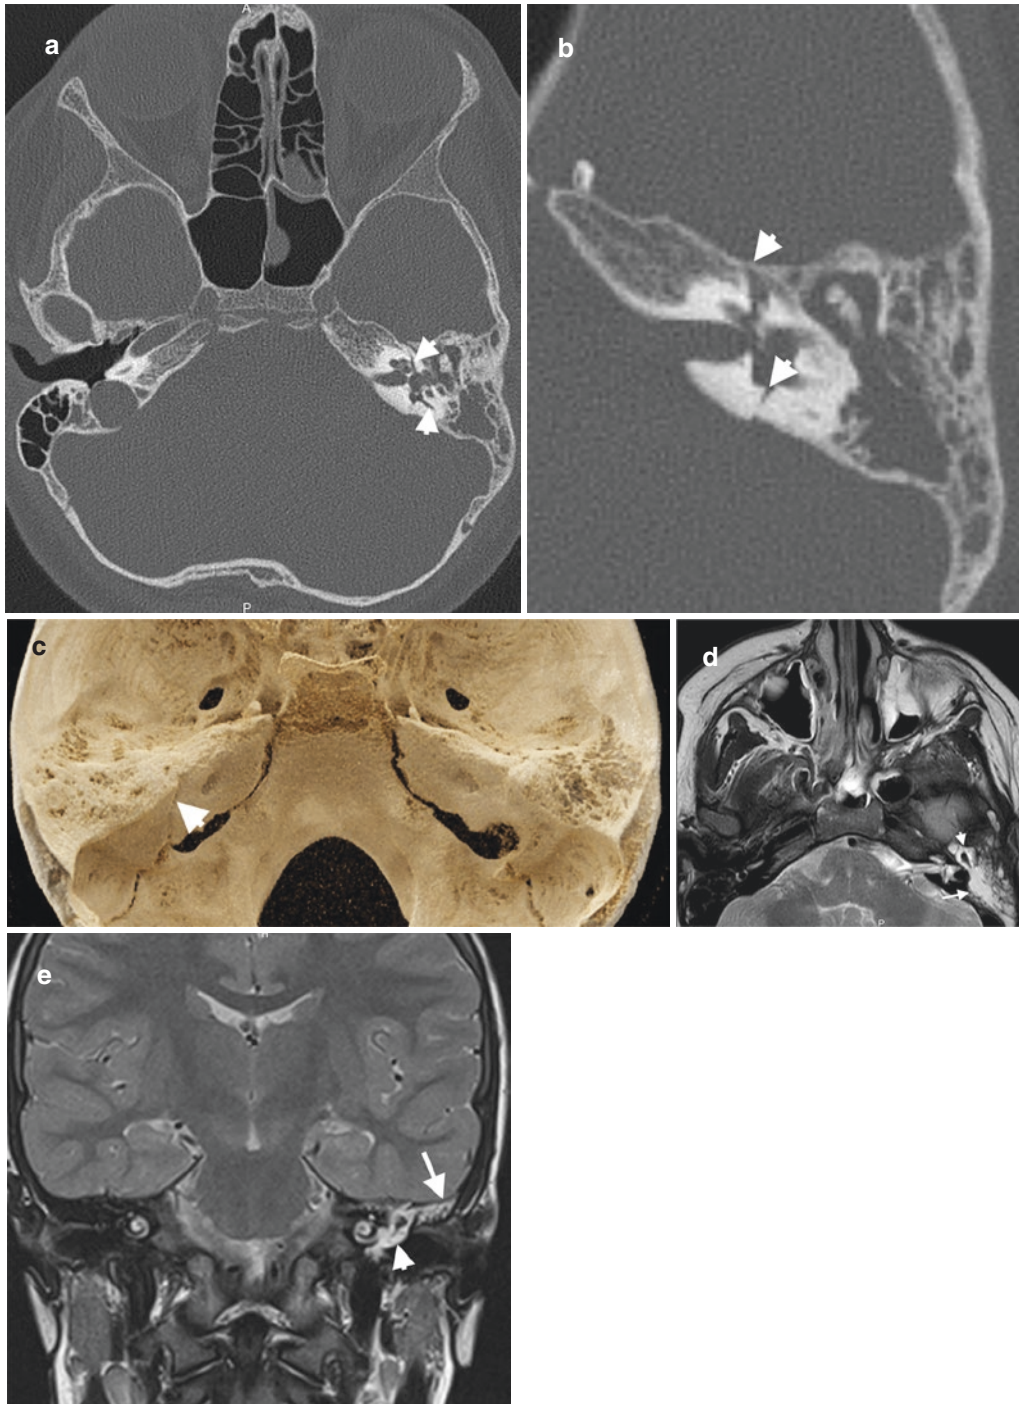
Otic capsule-violating temporal bone fracture in an 8-year-old male patient with a history of MVA. (a) Axial CT image demonstrates a horizontally oriented fracture violating otic capsule (arrowheads) in the left temporal bone. (b) Enlarged axial view shows hemotympanum and hemomastoiditis with horizontal fracture (arrowheads) traversing petrous portion of the temporal
